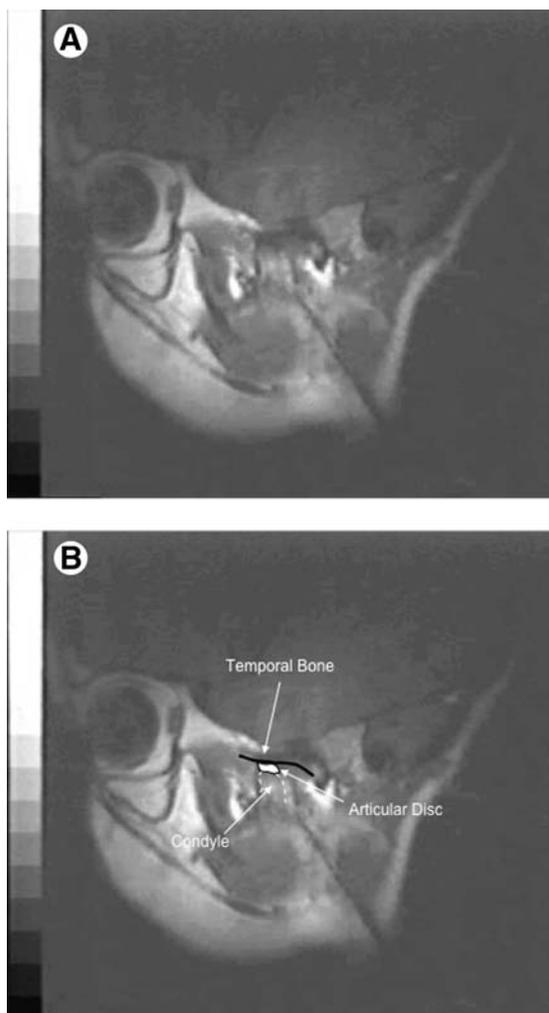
(A) The preoperative MRI in an open position of the TMJ of a second patient diagnosed with CFM showing the abnormal anatomy and displacement of the TMJ components. (B) Outline and labels for A.
